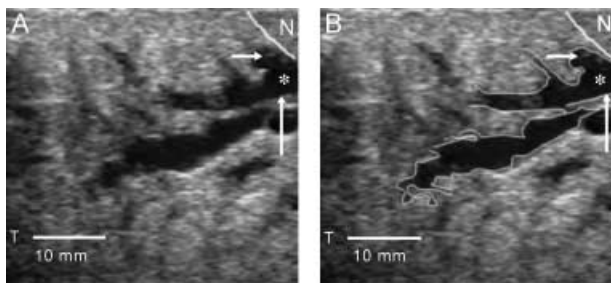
(A) Ultrasound image of milk duct in the lactating breast. The duct appears as branching hypoechoic structure within echogenic glandular tissue. (B) The ducts focused on in this scan are outlined in white. The duct is traced from the nipple (N) to the periphery of the breast. The walls are echogenic (↑) and the lumen hypoechoic (asterisk). The first branch of this duct (→) is imaged almost directly under the nipple.
